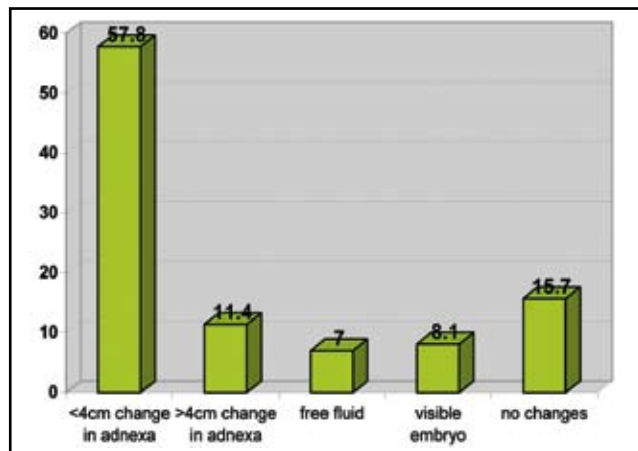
Ultrasound image in the group of women with ectopic pregnancy
